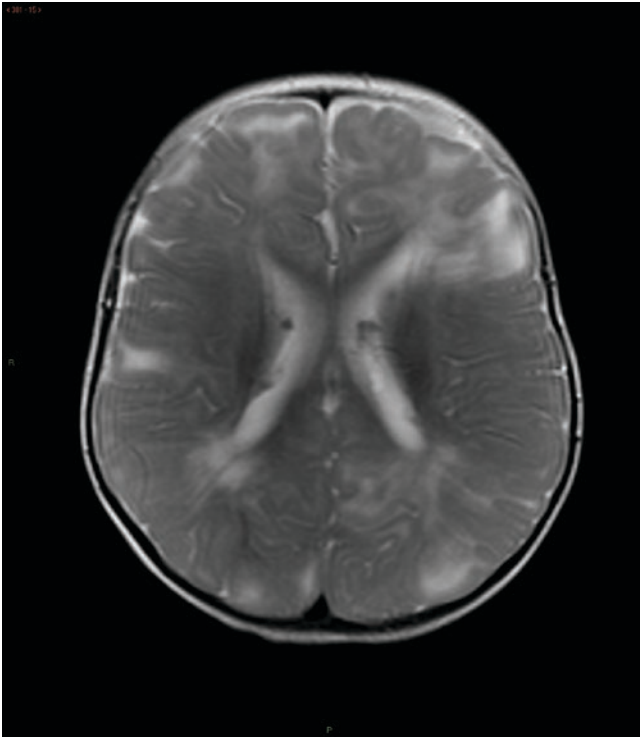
Tuberous sclerosis. Axial T2-weighted MR image demonstrates high-signal lesions within the brain consistent with cortical tubers, with low-signal subependymal nodules along the lateral ventricles
